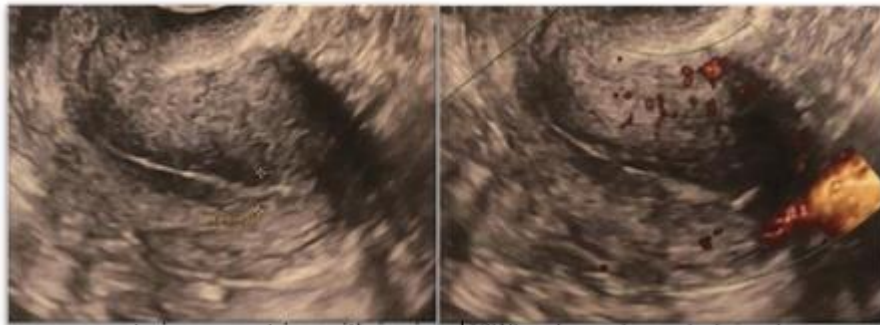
Pos-operative normal ultrasound
